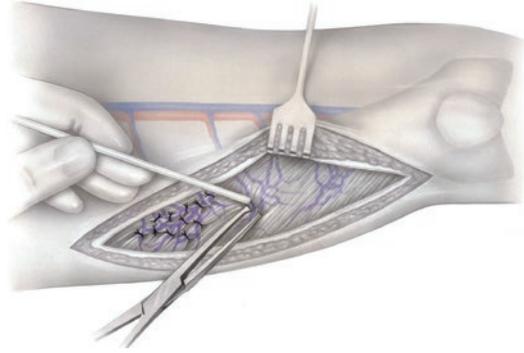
Extratruncular diffuse infiltrating AVM not to be sufficiently treatable by interventional techniques can be treated by the surgical technique according to Loose: before surgery the AVMs are identified by color. Doppler imaging and precisely marked on the overlying skin. During surgery ultrasonic Doppler mapping of AV fistulas, clamping, and over-and-over sutures of the AV fistulas and directly afterward ultrasonic control of the complete closure of the AV fistulas. This has to be continued until every AV fistula of the specific region is closed up
